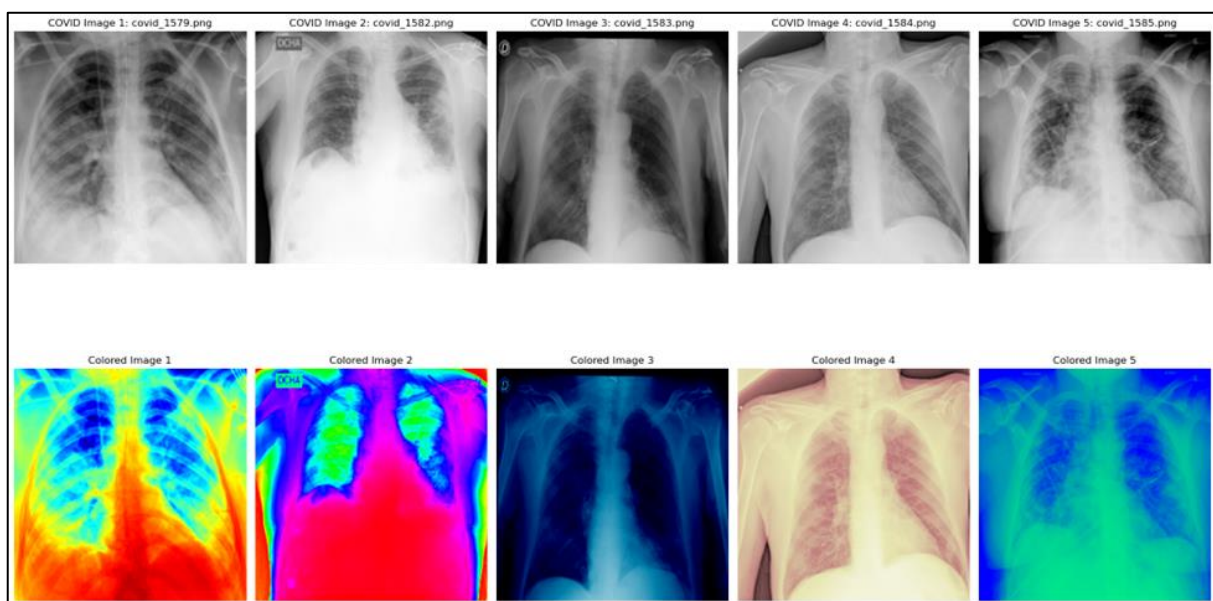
Sample X-ray images from COVID-19 positive patients (top five).
